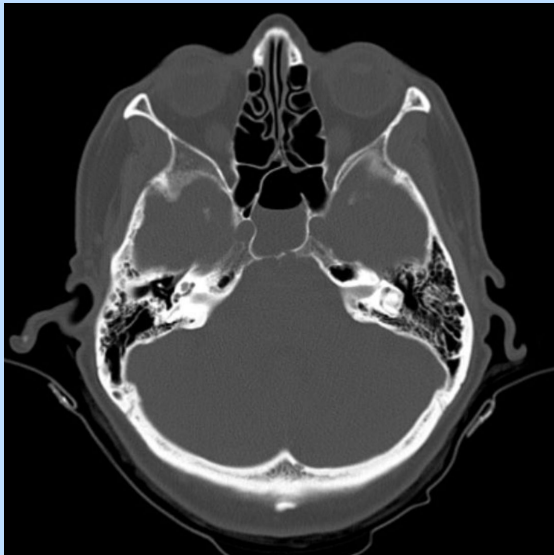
Initial CT w/o contrast
